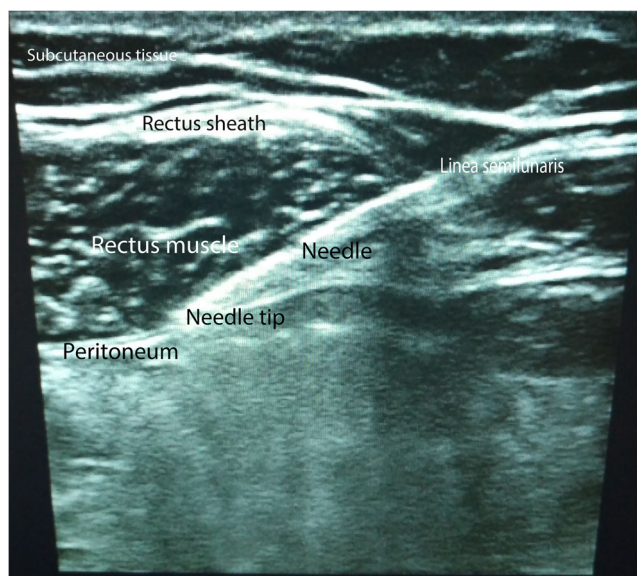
US-guided RS block. Ultrasound image of the anatomical structures relevant for the rectus sheath block. Local anesthetic is injected so as to lift up the rectus muscle
